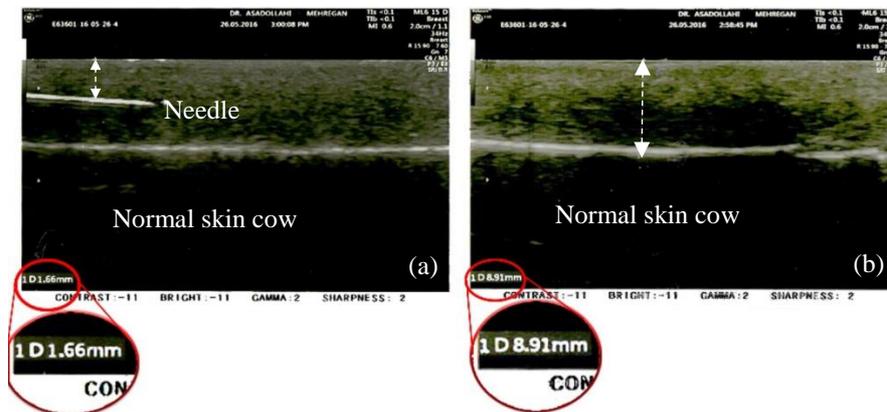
Measuring skin thickness: (a) Unhealthy and (b) Healthy with an ultrasonic device
